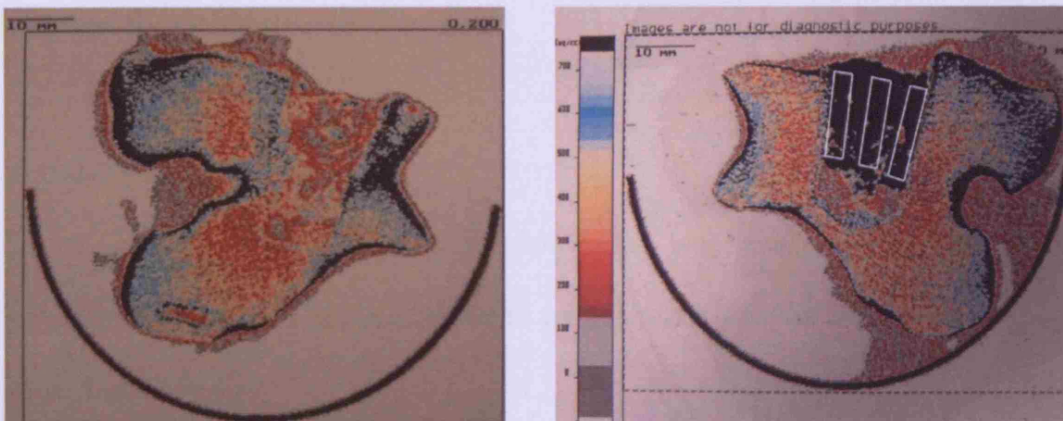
CT Images of Allograft (left) and HA (right). BMD was calculated for the 3mm wide areas marked on the right image.
